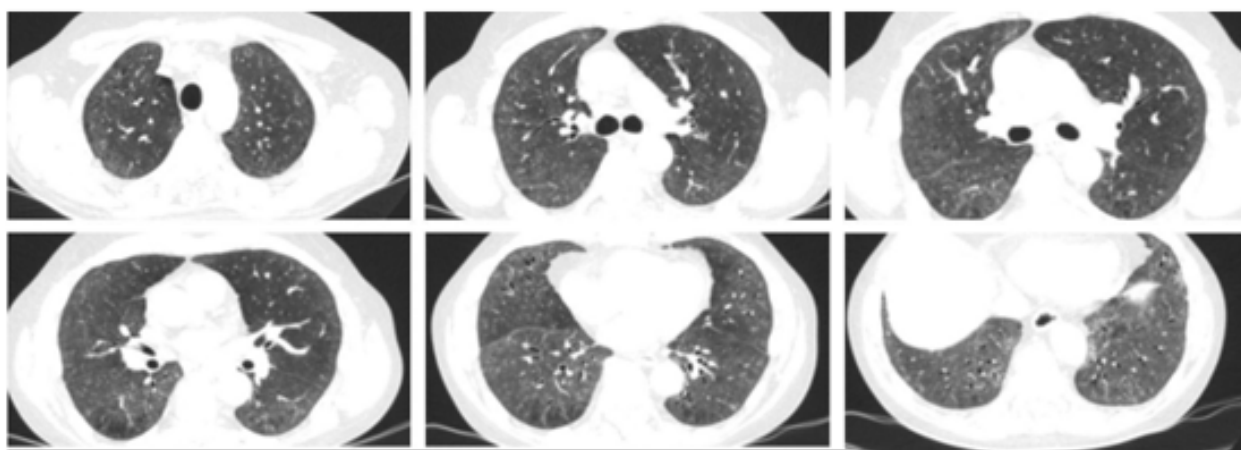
Axial HRCT images from 2019., showing only discrete areas of ground glass opacification.
